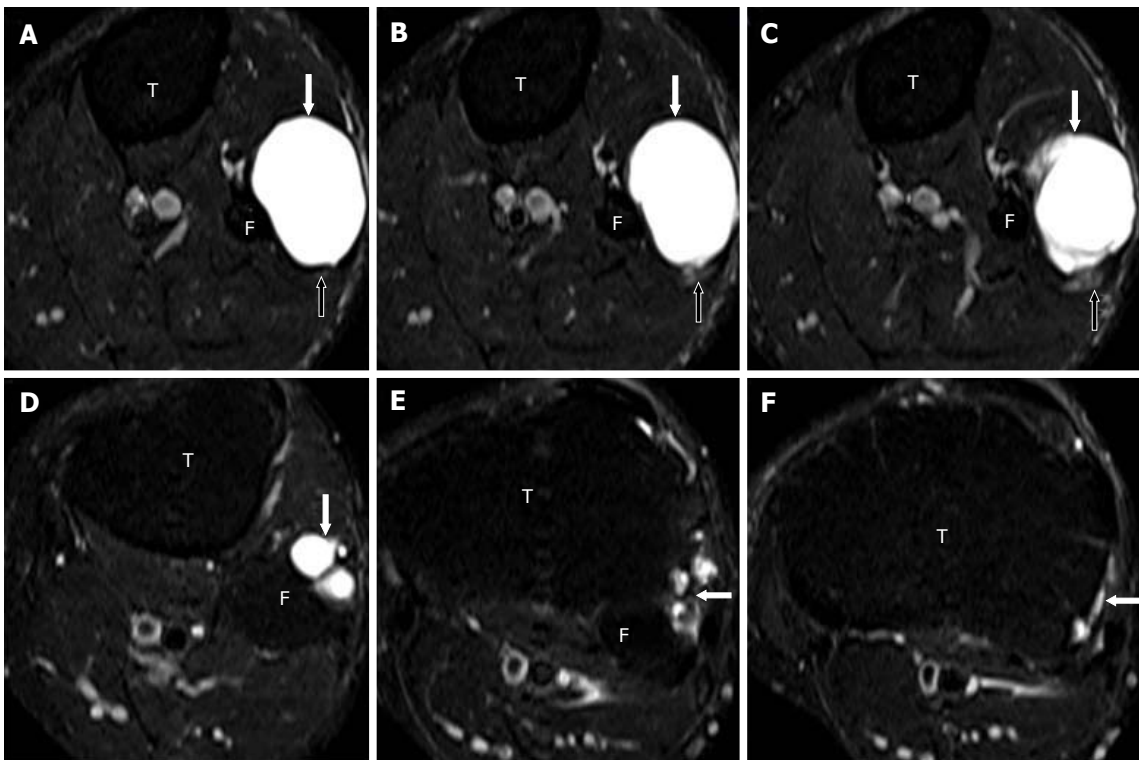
Images A-F show serial, T2-weighted fat suppressed axial sections of the proximal leg and demonstrate a large multilobulated globular extra-neural ganglion cyst (block arrows). The ENG is antero-lateral to the proximal fibula and indenting the peroneus longus muscle anteriorly (A-C). The CPN (open arrows) lies posterior to the cyst but is seen separate from it. The tail of the cyst (arrows in D-F) extends superiorly and communicates with the superior aspect of the PTF joint. PTF: Proximal tibiofibular; CPN: Common peroneal nerve; ENG: Extranural ganglion cyst; T: Tibia; F: Fibula.
